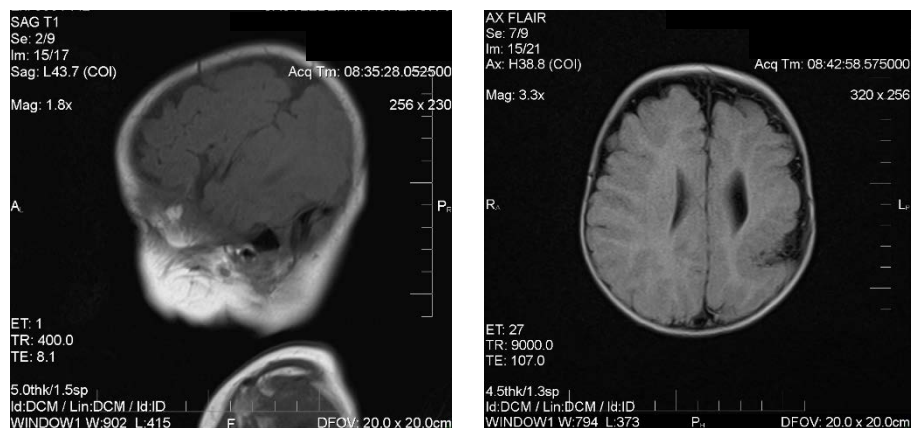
MRI sagittal and axial views; impressions indicative of features consistent with Unilateral Perisylvian Syndrome and extensive polymicrogyria tracking at left sylvian fissure.
